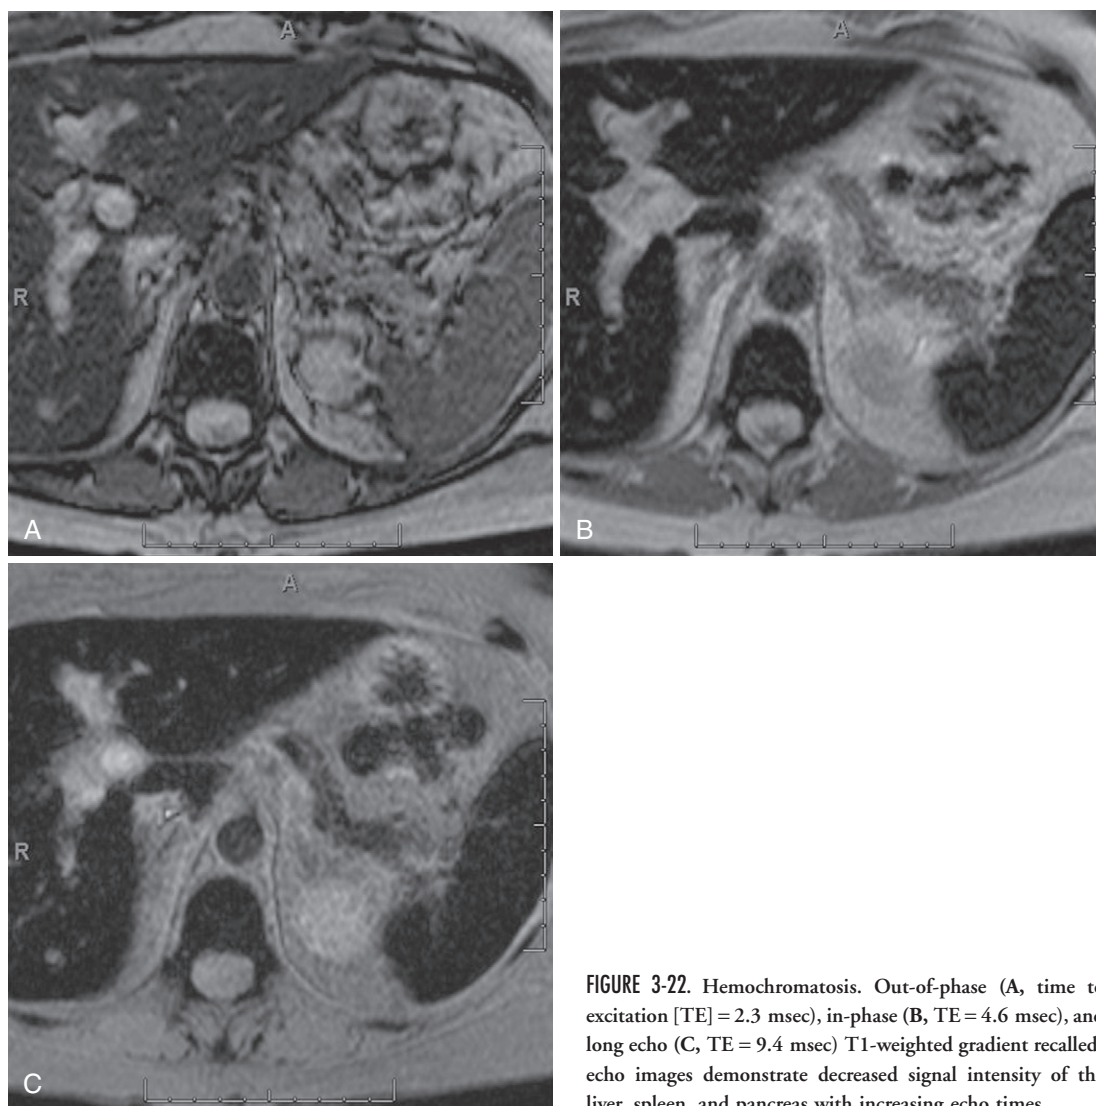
Hemochromatosis. Out-of-phase (A, time to excitation [TE] = 2.3 msec), in-phase (B, TE = 4.6 msec), and long echo (C, TE = 9.4 msec) T1-weighted gradient recalled-echo images demonstrate decreased signal intensity of the liver, spleen, and pancreas with increasing echo times.
